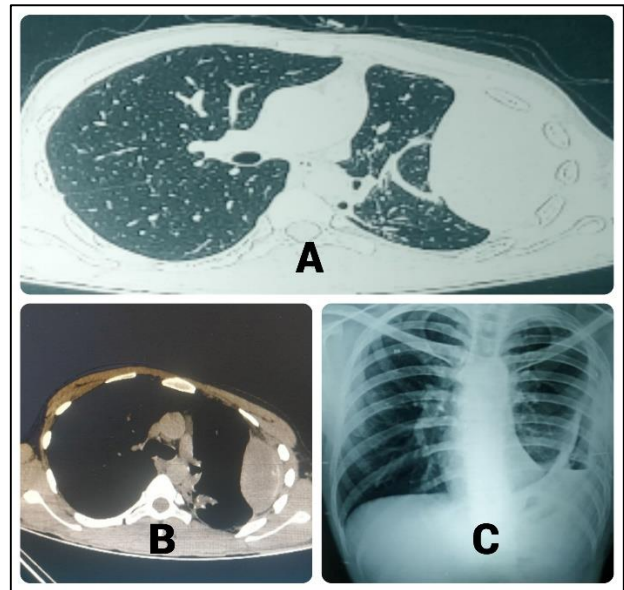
(A-C): CT thorax showing loculated pleural effusion causing passive collapse of the left lower lobe. Multiple focal calcifications and thickening of visceral and parietal pleura. Chest x ray taken post ICD insertion.
